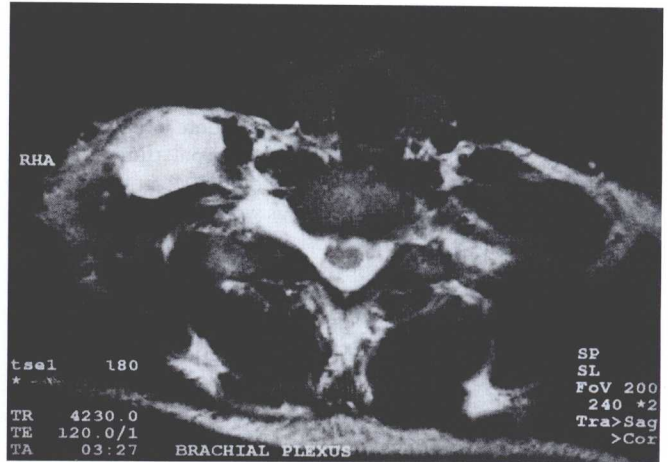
Magnetic resonance image (axial, T2 weighting) showing a right-sided pseudomeningocele resulting from traumatic avulsion of one of the roots of the brachial plexus.
